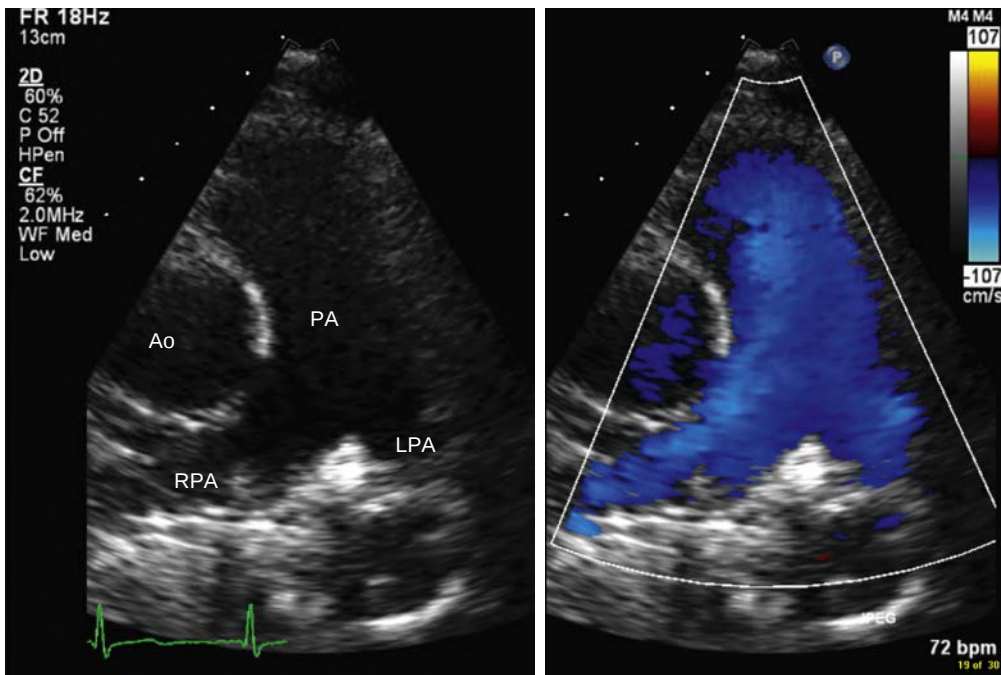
RV outflow view. The 2D and color Doppler RV outflow view, obtained by angulating the transducer laterally from the parasternal long-axis view, shows the RV outflow tract, pulmonic valve, main pulmonary artery (PA), and left and right branch pulmonary arteries (LPA and RPA). Ao, Aorta.
